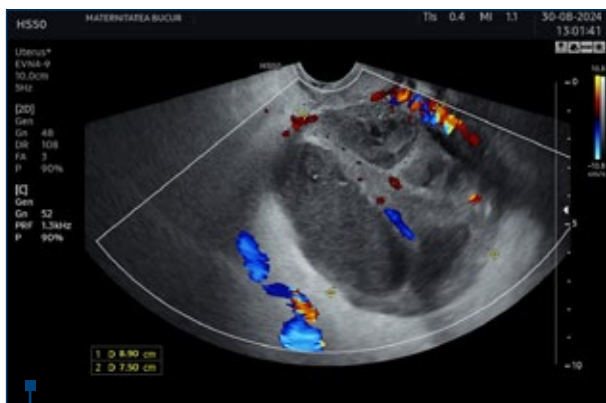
Left adnexal mass measuring 89/75 mm, with heterogeneous content, thick, coarse septa, and grade 1-2 color Doppler signal
